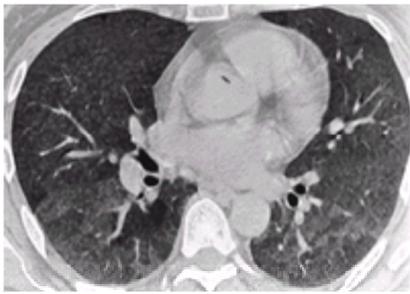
High-resolution CT of a nonsmoker with exposure to both birds and shells who had progressive dyspnea, weight loss, hypoxemia, and a restrictive ventilatory defect. Note the diffuse nodular radiodensities in the lower lobes with areas of ground-glass densities posteriorly.
